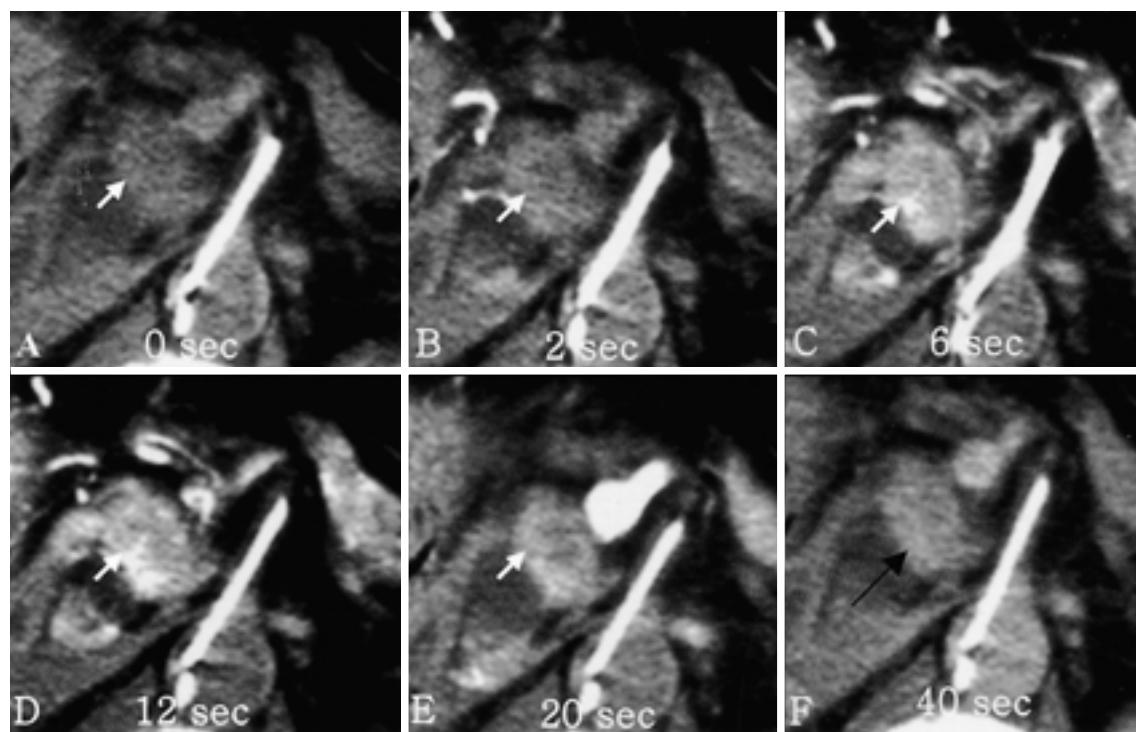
Single-level dynamic CT scans obtained before (A) and 2 seconds (B), 6 seconds (C), 12 seconds (D), and 20 seconds (E) after contrast infusion through celiac axis and superior mesenteric artery show persistent hypoattenuating central portion of the mass and progressive enhancing periphery (arrows), but 40 second scan (F) shows decreased enhancement of the peripheral portion of the tumor (long arrow).
